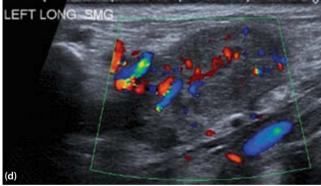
IgG4related systemic disease. (a) Enlarged, bilateral lacrimal glands; (b) Symmetric bilateral parotid gland enlargement; (c) Bilateral heterogeneous glands with hypoechoic regions; (d) Hyperaemic glandular parenchyma; (e) Contrast CT (coronal) shows pancreatitis and hepatosplenomegaly with an obstructed CBD.
